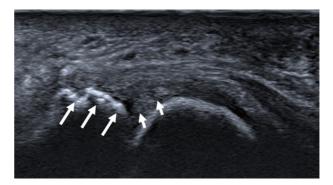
Sagittal ultrasound image demonstrating second MTP joint lateral plantar plate degeneration manifest as mildly heterogeneous hypoechoic echotextural change toward the proximal phalangeal insertion (short arrows). Note the adjacent entheseal bony irregularity at the base of the proximal phalanx (long arrows) that was only readily appreciable on dorsiflexion of the second MTP joint.
